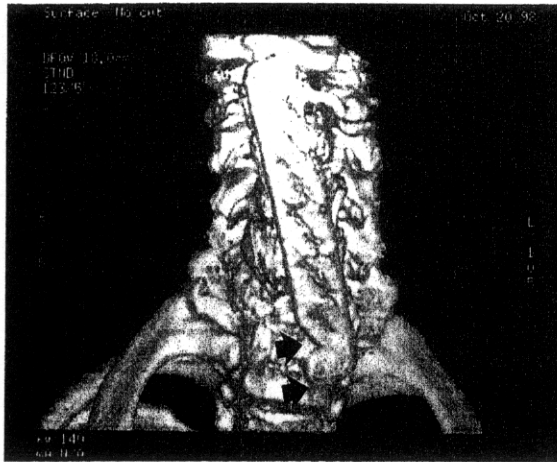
Case 2: At 6 weeks following a C2-C7 ACF/C2-T1 PWF performed with a fixed plate/fixed screw plating system in a patient with severe cerebral palsy, the plate extruded inferiorly into the left side of the C7-T1 interspace. However, the strut was still in continuity with the caudal C7 vertebral body. After 6 months, once the parasagittal 3D-CT study confirmed strut fusion to the surrounding bony callous, the anterior plate was removed for persistent dysphagia
